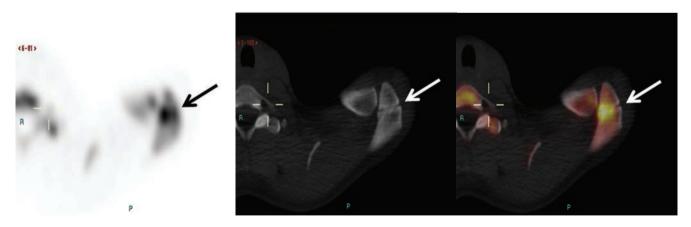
The 18F-Fluoride PET-CT showed a focus of moderate grade activity on the left shoulder which on axial images localized to the lateral end of the left acromion (black arrow) corresponding on CT to a linear defect with subtle sclerotic margins (white arrow) in keeping with os acromiale
